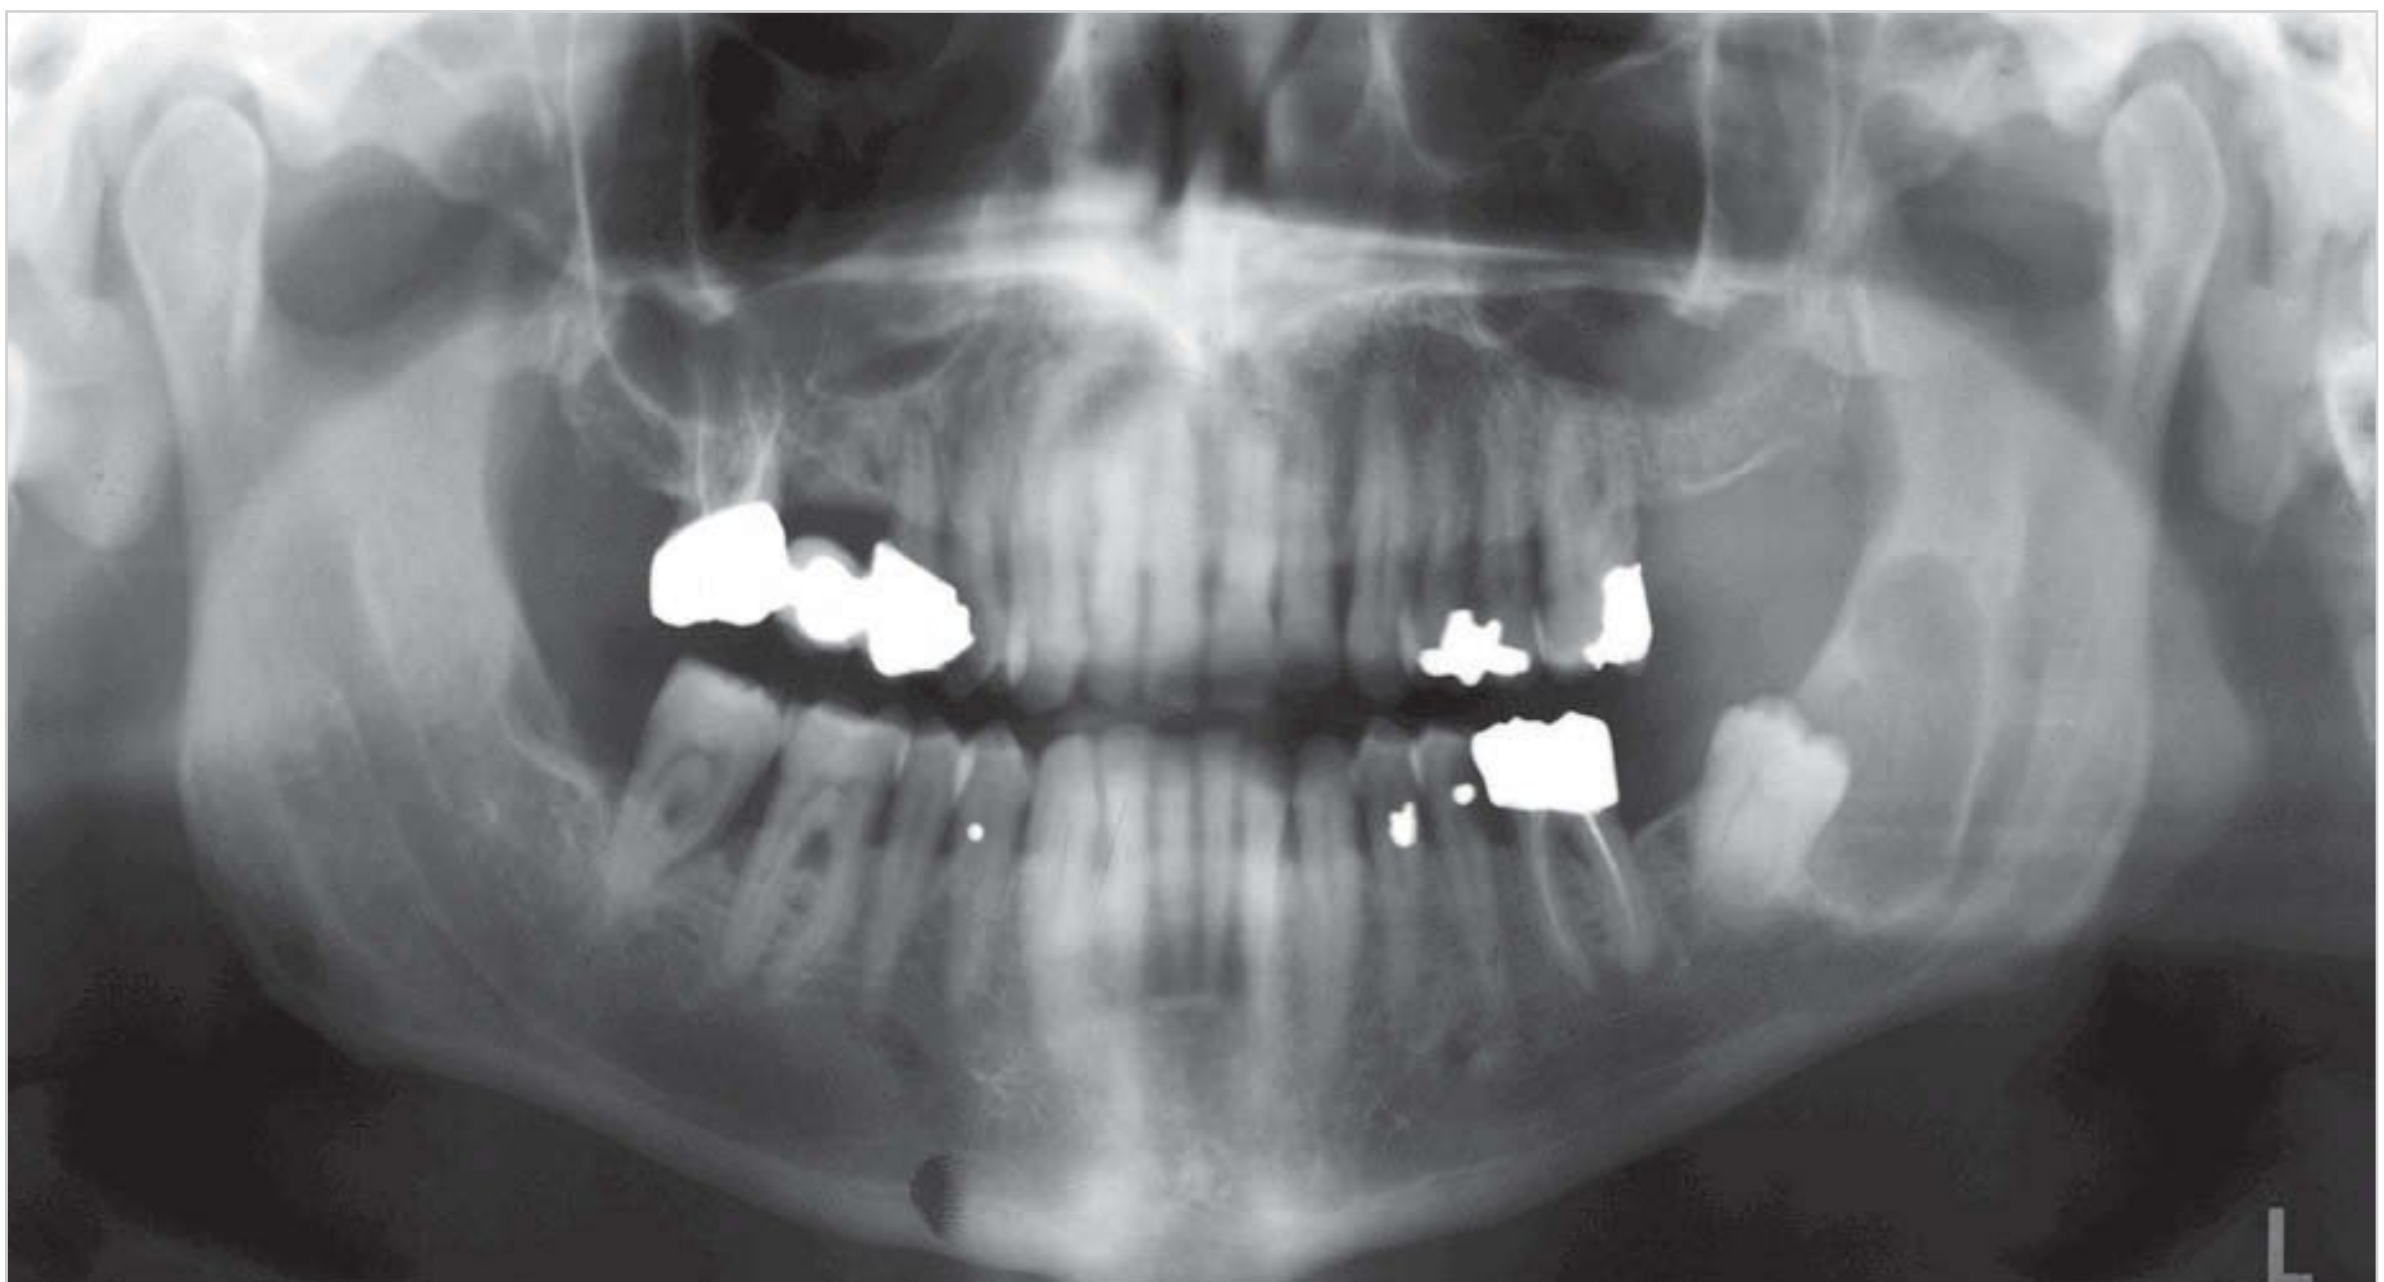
Typical keratocystic odontogenic tumor with an adjacent tooth. The tumor displaces the tooth but is not attached to it. This type of radiographic constellation can easily be misinterpreted as a follicular cyst.
